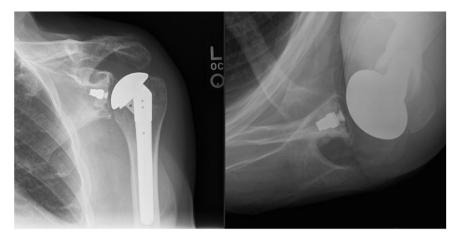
Radiographs at 20 weeks show evidence of acromial deformity on the Grashey view and possible fracture line on the axillary view.
